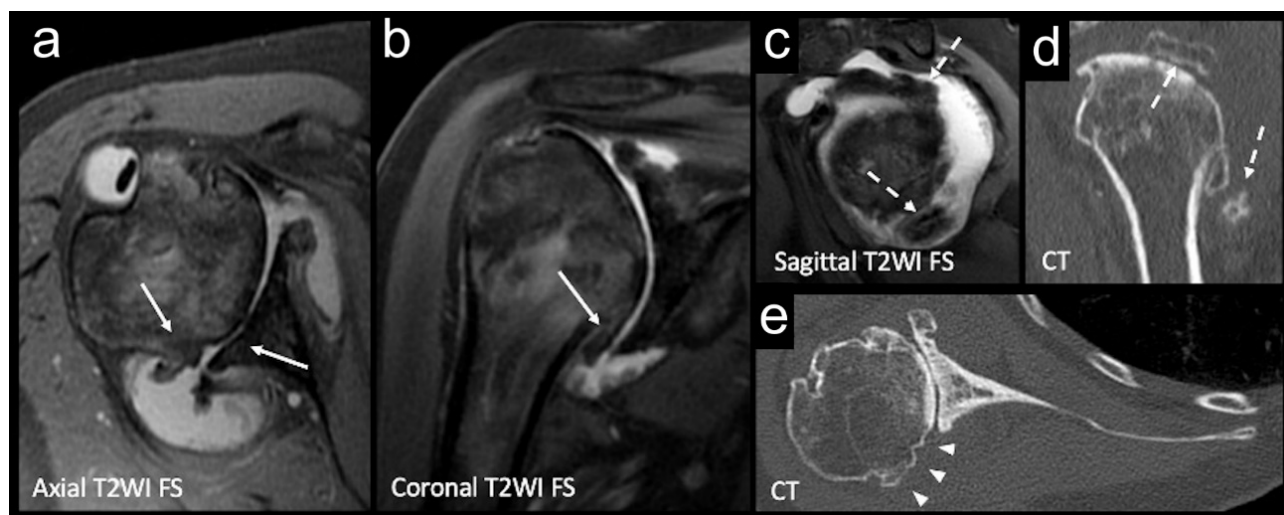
A 78-year-old woman with chronic right shoulder pain who was found to have advanced glenohumeral osteoarthritis. (A–C) Fat-saturated T2-weighted MRI sequences showing diffuse, irregular chondral thinning, posteroinferior marginal osteophytes (arrows), bone remodeling, and light subchondral edema. There are also joint effusion, synovitis and intra-articular ossifications (dashed arrows). (D,E) Those features were also observed on a concomitant CT scan of the shoulder. Notably, glenoid retroversion, humeral subluxation, and medialization were also observed (arrowheads).
